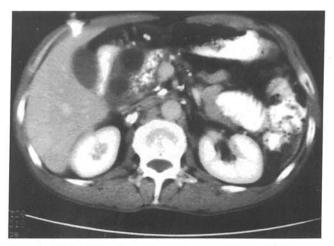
CT appearance of wall thickening in terminal
